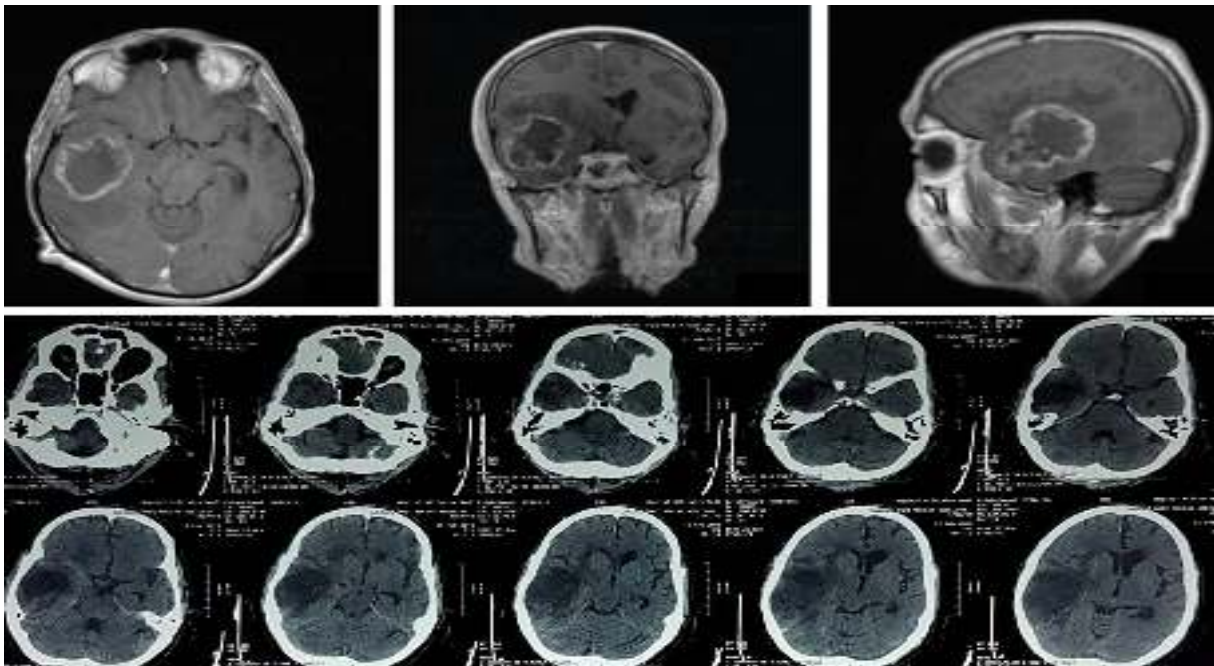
T1WI with gadolinium in axial, coronal and sagittal plan showing the large temporal tumor with cystic component and enhancing rim. Below is the axial CT scan imaging without contrast performed 1 week after the stereotactic biopsy showing the enlargement of the cyst and the surrounding edema.
